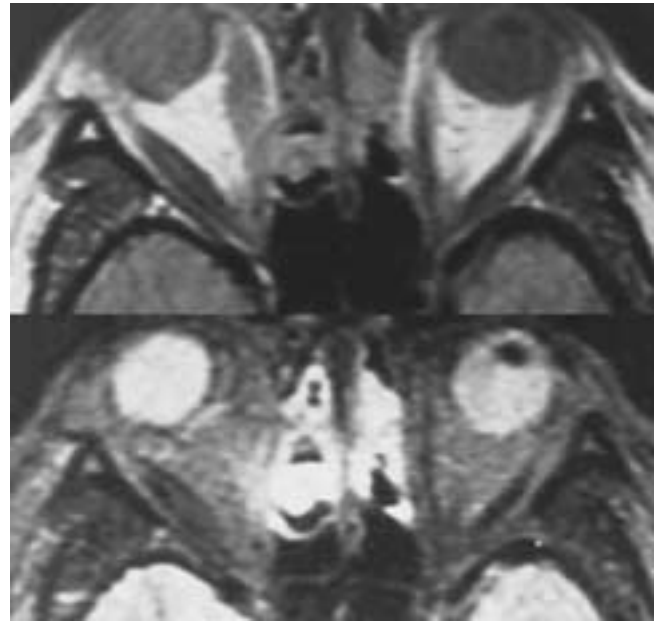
Pseudotumor (myositic type), axial PW (*top*) and T2-weighted (*bottom*) MR scans in another patient show enlargement of the right lateral and medial rectus muscles.
